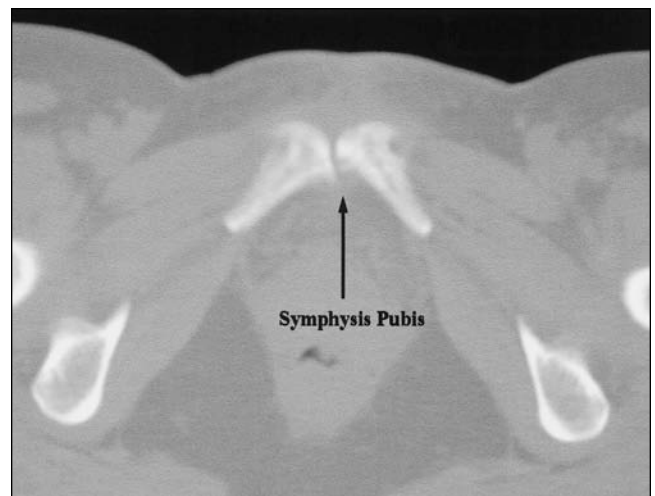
CT scan of the pelvis highlights the irregular joint line of the pubis symphysis joint.
